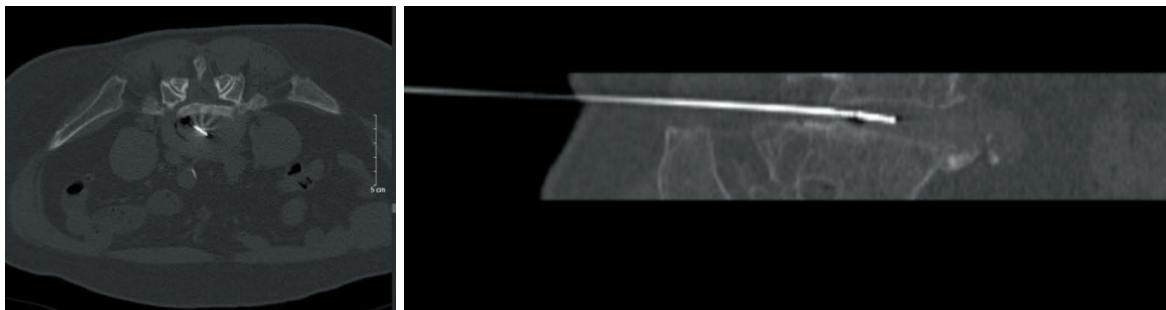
Percutaneous plasma decompression of the L4/5 disc under CT guidance, August 10, 2024.
